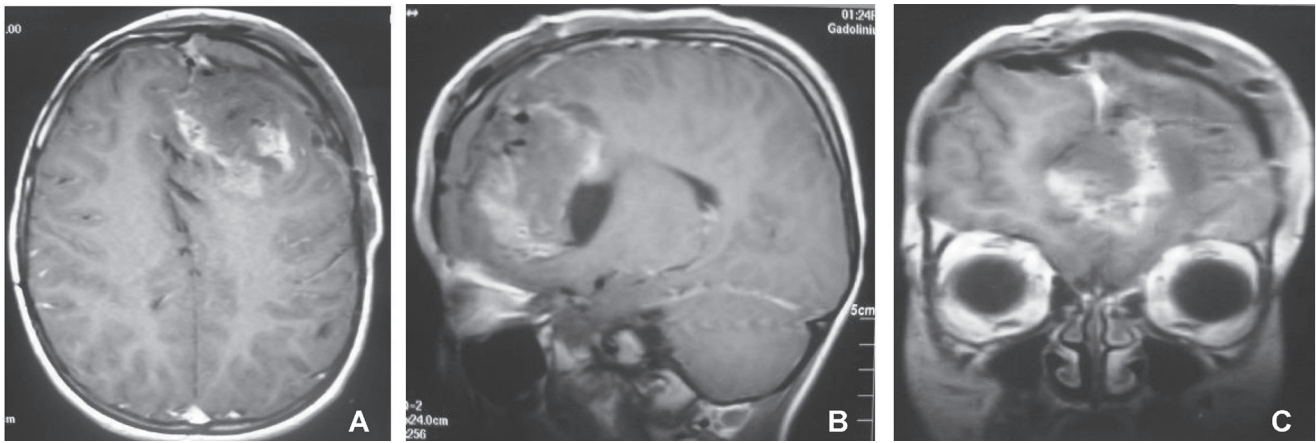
Postoperative axial, sagittal and coronal magnetic resonance images of the brain, showing the resection of the mass.
